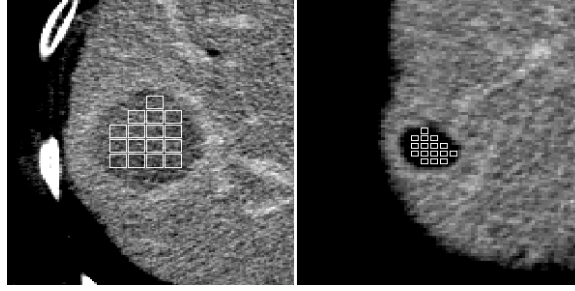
CT images of liver. On the right detail of hepatocellular cancer focus with fitted texture samples (windows of 9 x 9 pixels), on the left liver cyst with embedded texture samples with size 7 x 7 pixels.
